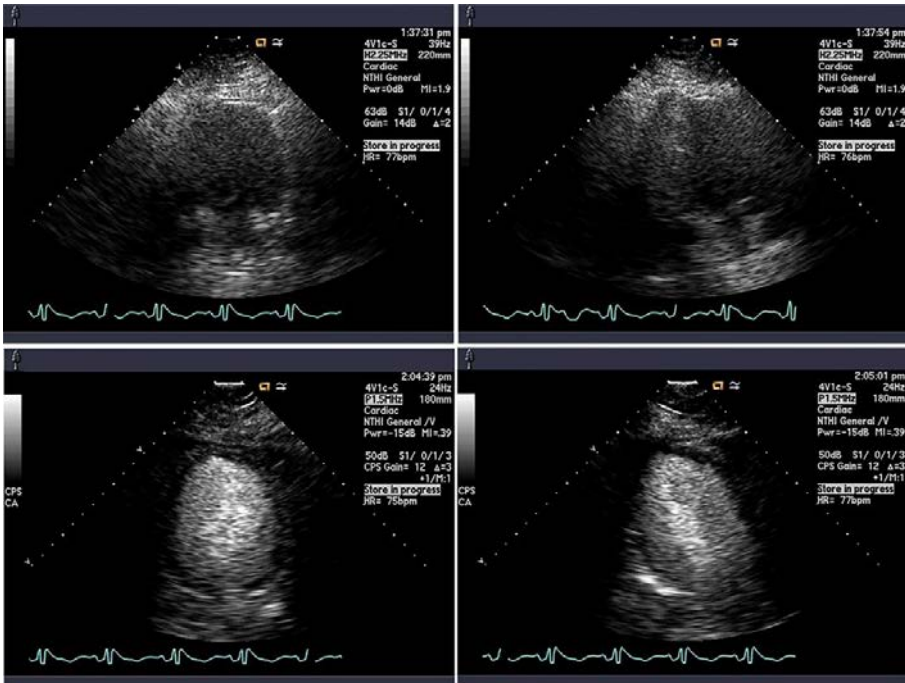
Echocardiographic study using intravenous microbubble contrast.
